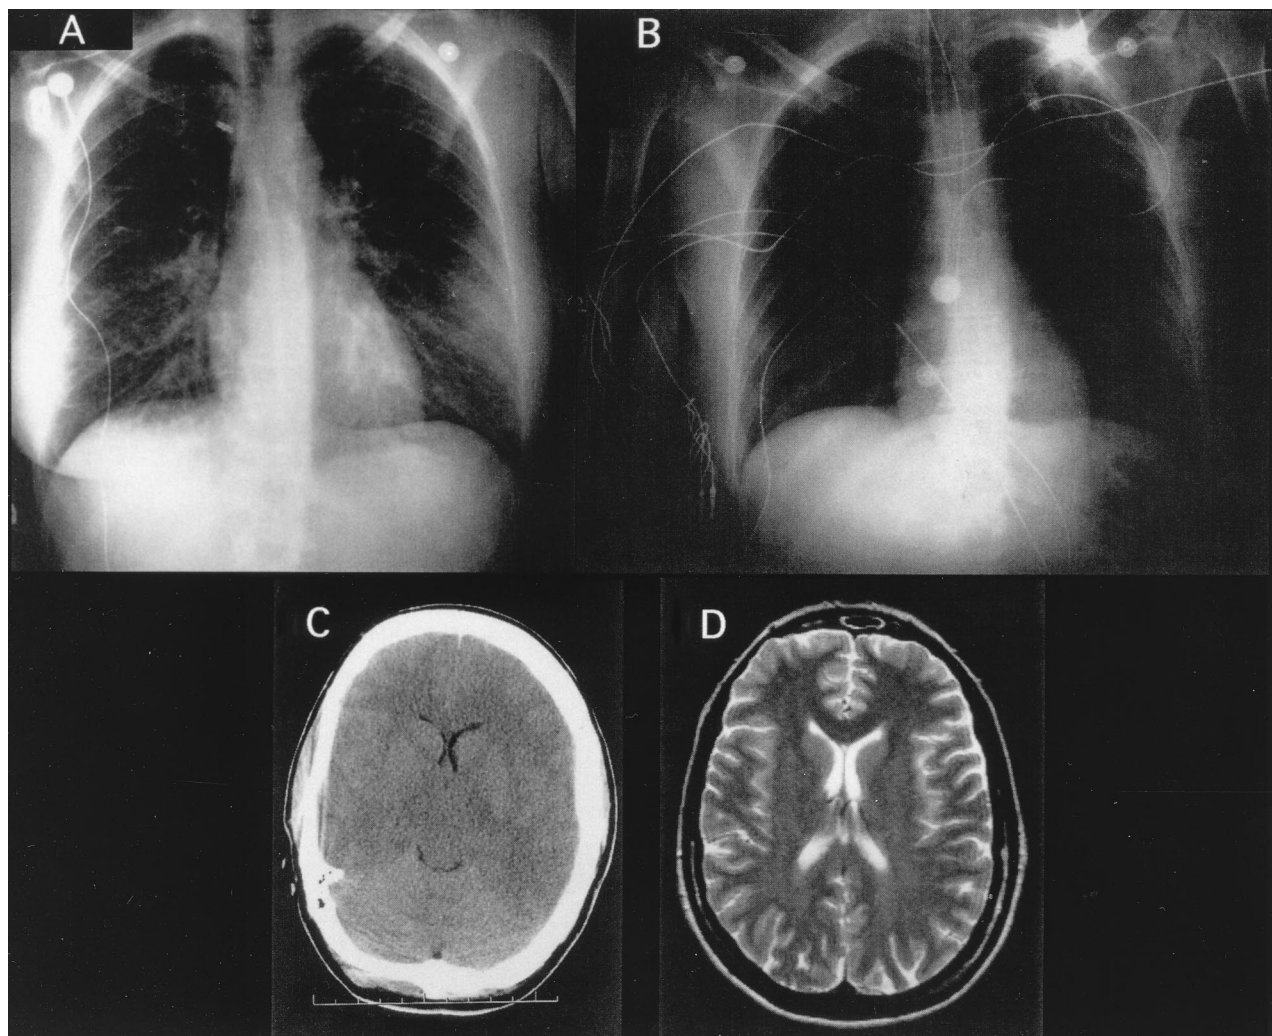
Radiographs and scans obtained from patient 3, a 44-year-old woman who was admitted to the emergency department with a plasma sodium level of 121 mmol/L and oxygen saturation of 66%. Bibasilar rales and copious pink frothy sputum were noted, and the respiratory rate was 38 breaths/min. A. Chest radiograph showing interstitial edema and apparent redistribution of pulmonary blood volume, with loss of distinct vascular margins. The heart size is normal. B. Chest radiograph obtained 24 hours after admission. The patient's plasma sodium level had been increased from 121 to 129 mmol/L in 9 hours. The patient was alert and responsive, with oxygen saturation of 97%. The chest radiograph is normal. C. Computed tomographic scan of the brain obtained within 1 hour of the chest radiograph shown in part A. Cerebral edema is evident, the cerebral ventricles are essentially obliterated, and the sulci are largely absent. D. Magnetic resonance image of the brain taken 24 hours after admission, at about the same time as the chest radiograph shown in part B. Cerebral edema has resolved, the cerebral ventricles are now clearly visible, and the sulci are more distinct.
